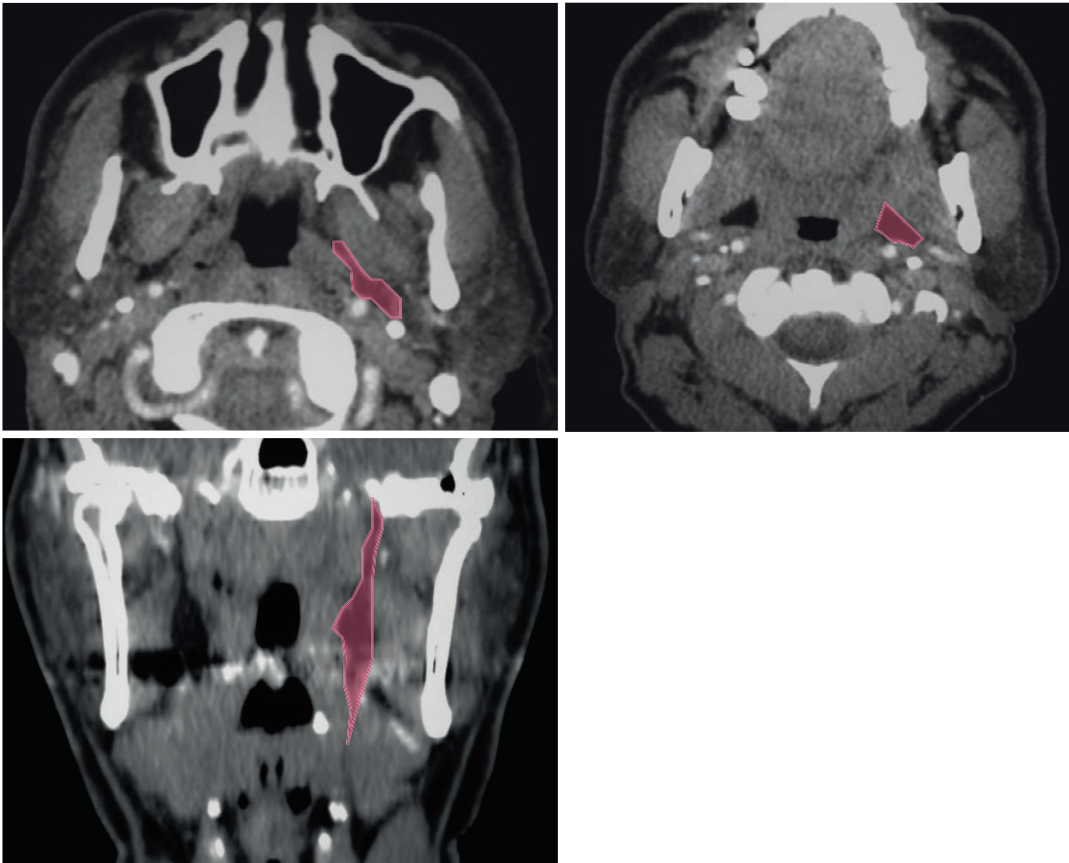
Axial and coronal CT images demonstrate the extent and location of the parapharyngeal space in pink
